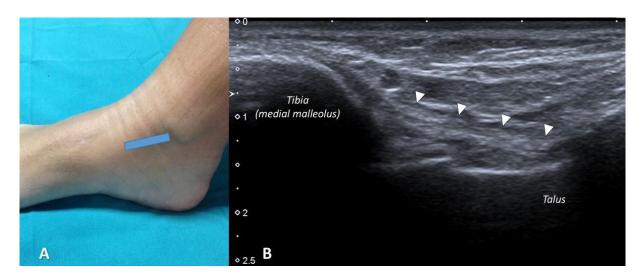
A) Probe positioning for scanning the posterior bundle of the deltoid ligament. B) Longitudinal ultrasound scan of the posterior tibiotalar ligament (arrowheads).
